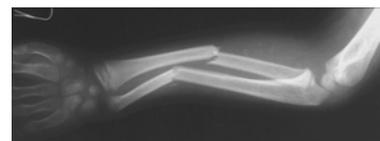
X-ray of midshaft forearm fracture
